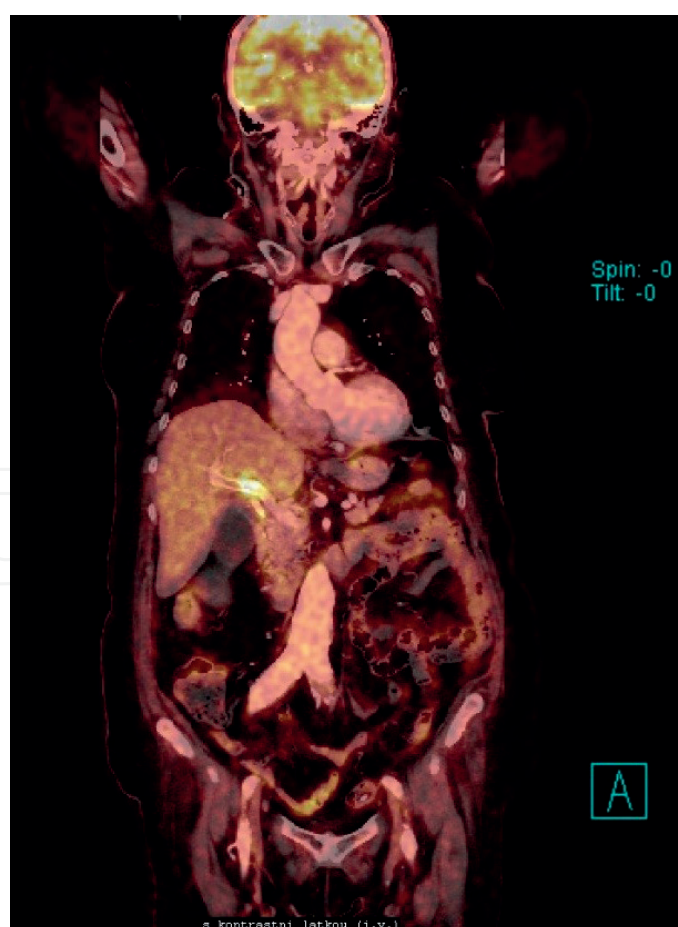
Klatskin tumor and AAA (PET CT).
